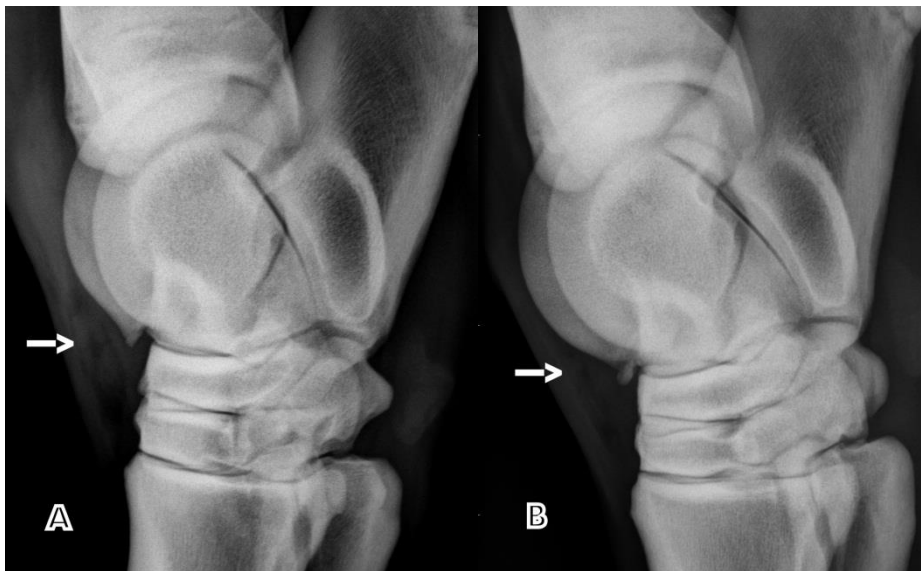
Lateromedial radiographic view of tarsus showing variations in the appearance of the distal medial trochlear ridge, (A) attached protruberance (arrow) and (B) a fragment (arrow).
